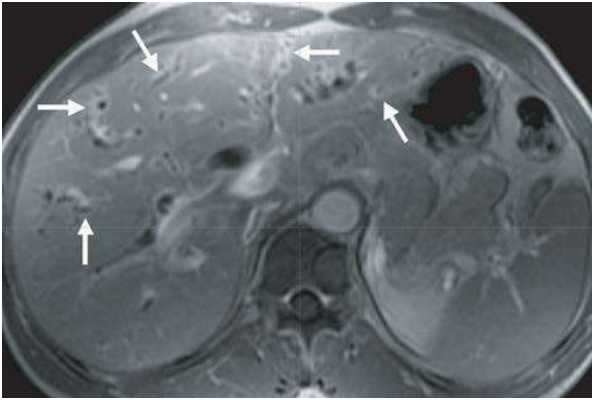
Periductal enhancement of mildly dilated intrahepatic bile ducts (arrows) on hepatic arterial phase of dynamic study of gadolinium-enhanced transverse MR image, which possibly represents active infection⁴
